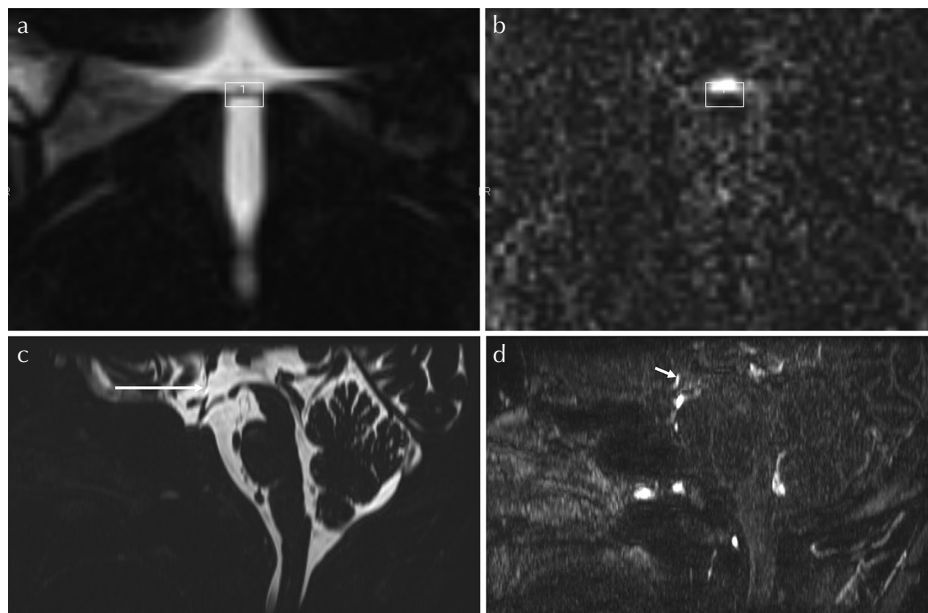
Example of ROI position. A rectangular ROI is positioned on the MR cisternography (a), centered on the band-like organum vasculosus of the lamina terminalis (OVLT). The axial slice of the ROI is positioned in the middle slice level between the anterior commissure and the optic chiasma levels. Then, ROI is copied and pasted onto the corresponding heavily T_2 -weighted three dimensional-fluid attenuated inversion recovery (3D-FLAIR) image (b). In this volunteer, the position of the enhancement is in the anterior part of the ROI. The mid-sagittal reformatted image of the MR cisternography (c) and that of the heavily T_2 -weighted 3D-FLAIR obtained 0.5 h after the intravenous single dose administration of gadolinium based contrast agent (IV-SD-GBCA) (d) are shown for anatomical orientation. The OVLT is visualized as the slit like low signal structure in the anterior wall of the third ventricle on the MR cisternography (arrow, c). Band-like enhancement (short arrow, d) just anterior to the OVLT is clearly visualized on the heavily T_2 -weighted 3D-FLAIR obtained 0.5 h after the IV-SD-GBCA.
